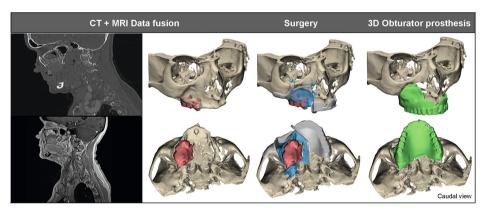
Tumour visualisation based on CT and MRI data fusion. CT images are used for 3D reconstruction of bone tissue, while the MRI enables delineation of the tumour. This enables preoperative planning of the bone resection (blue) and thereby guide design (grey). Pre-operative CAD/CAM manufactured obturator prosthesis (green) designed to obturate the defect following guided resection.
